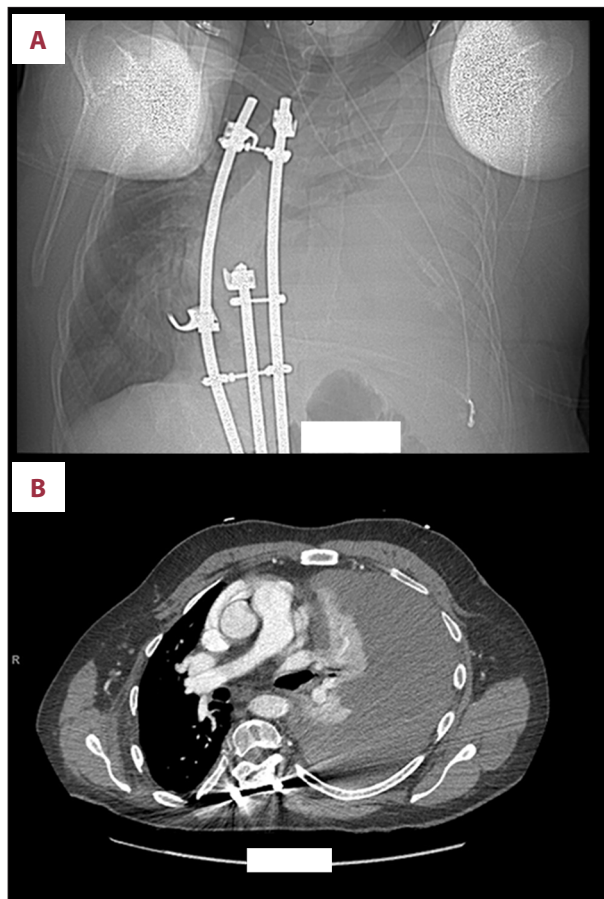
(A, B) Admission computed tomography scan: large left hemothorax without central pulmonary embolism.
